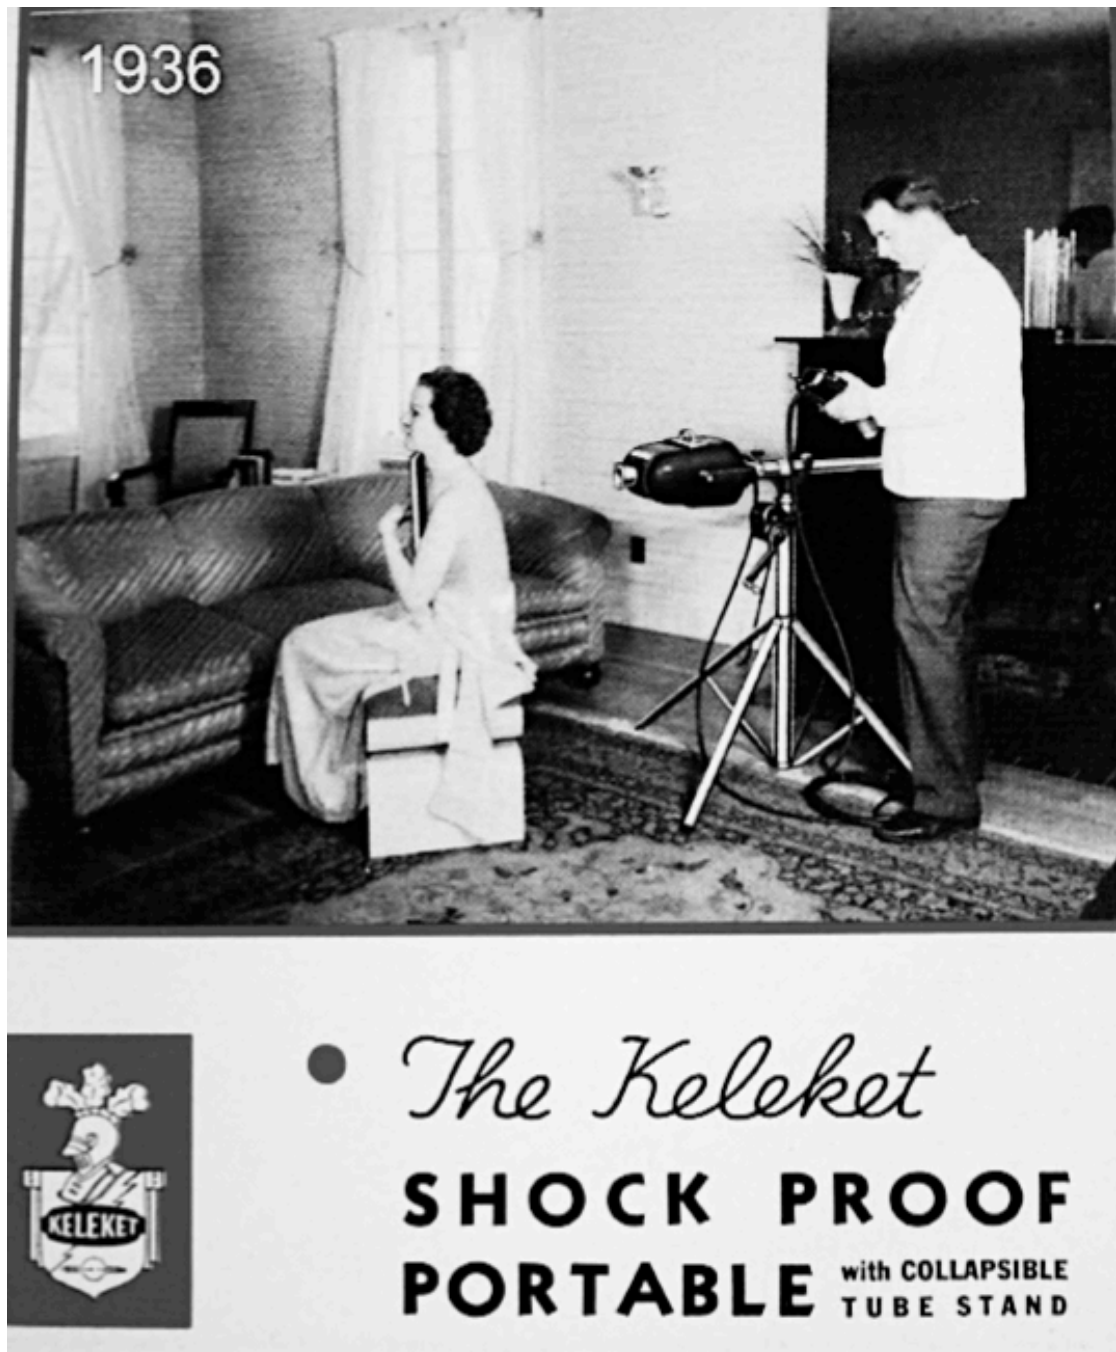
Advertising from the late 1930s appealing to a continued concern over electrocution and shocks from x-ray apparatus.⁵¹²
